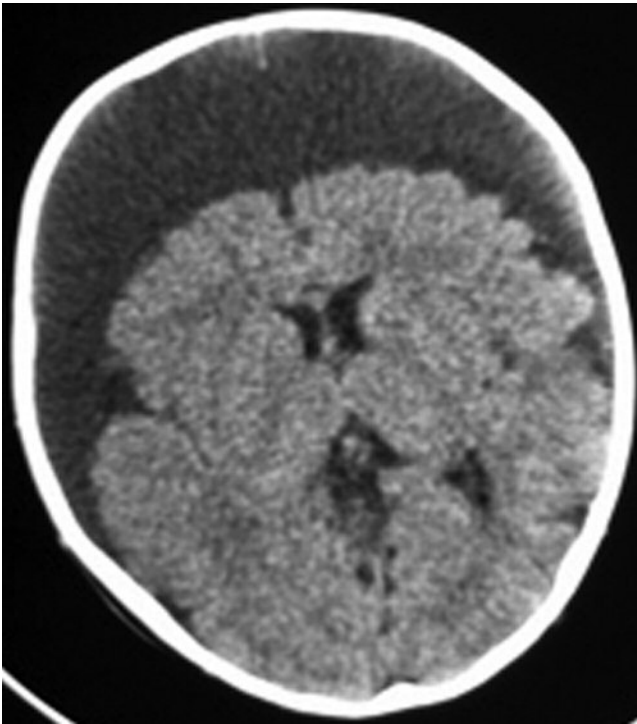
Noncontrast CT scan of brain at presentation demonstrating large bilateral chronic SDHs.
